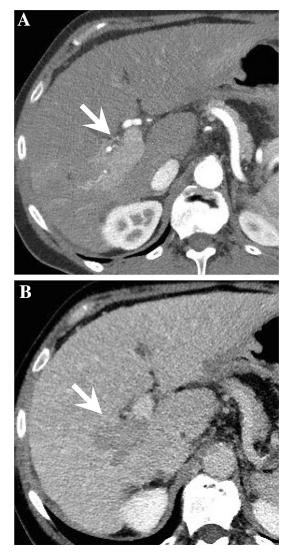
Tumor in vein (LR-TIV). Contrast-enhanced CT in the arterial (A) and portal venous (B) phases show an expansile enhancing soft tissue (arrow) in the right portal vein of a cirrhotic liver not contiguous with a parenchymal mass. This is consistent with LR-TIV, likely due to HCC. Note arterial phase hyper-enhancement and "washout" seen within the expanded vein. Case courtesy of Dr. Kupa Patel-Lippman.
